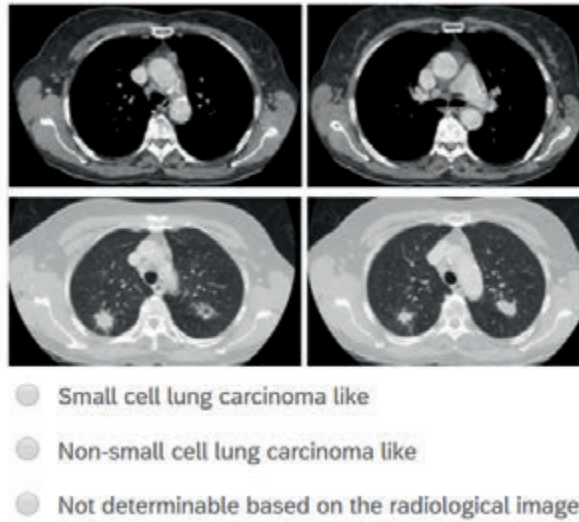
C Survey among pulmonary oncologists to give an interpretation of CT-scans to be small cell-like or non-small cell-like.
